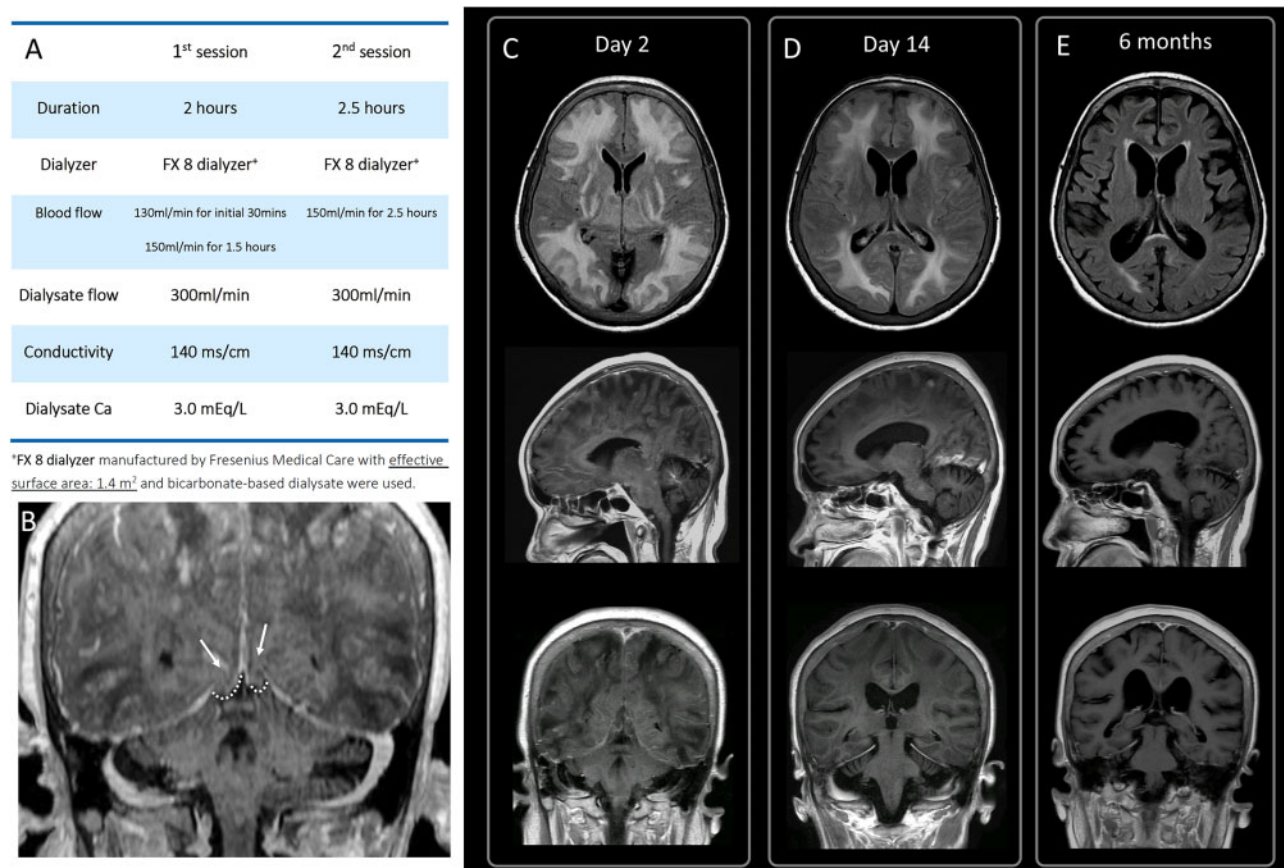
(A) Summary of the first two hemodialysis settings. (B) The T1-weighted coronal image showing profound swelling of the brain with uncus sliding over the edge of the supratentorial notch (arrows). (C–E) Serial MRI images on Day 2, Day 14 and at 6 months. (C) T2-weighted FLAIR images (upper) showing diffuse hyperintensity in the white matter; T1-weighted sagittal and coronal images (middle and lower) showing brain swelling and cortical sulcal effacement. (D) MRI on Day 14 showing partial resolution of white matter hyperdensity and recovery of cerebral edema with uncus herniations. (E) MRI obtained 6 months later showing nearly complete resolution of the white matter changes and restoration of the brain anatomical position.
